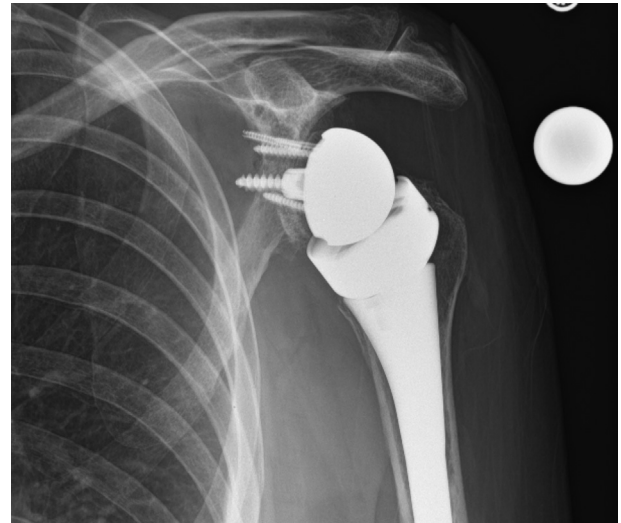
Anteroposterior postoperative radiograph of the left shoulder at 6 weeks after surgery showing appropriate healing and integration of the implant.
